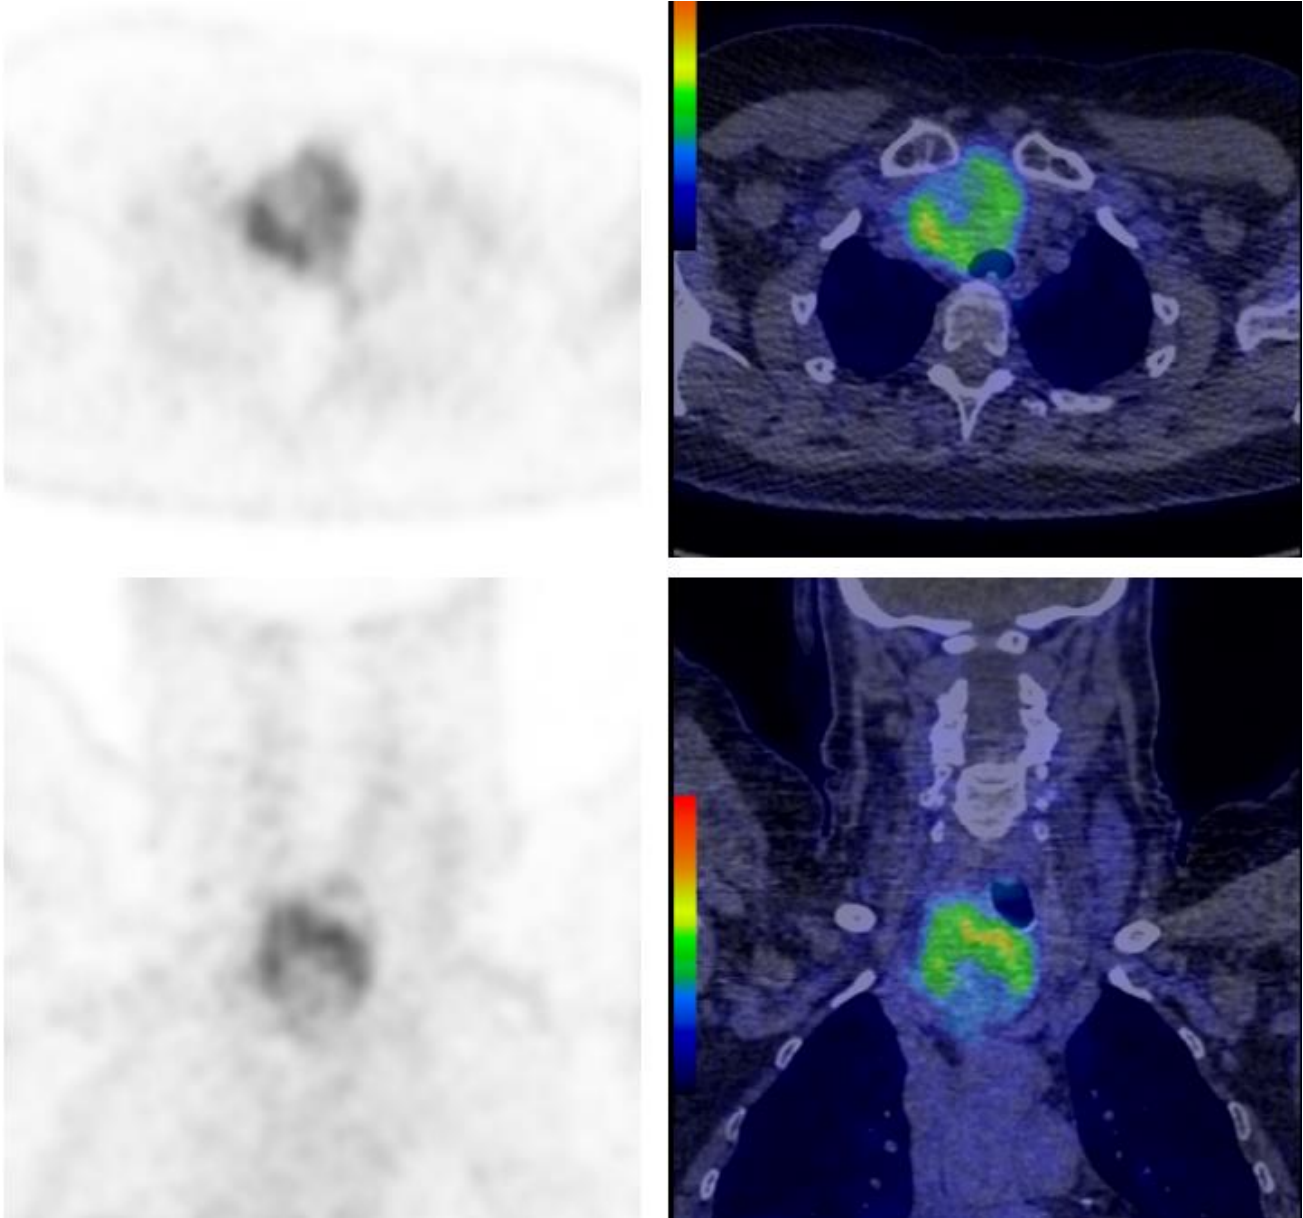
^{18}F DCFPyL uptake with low dose CT co-registration in the right thyroid lesion.
